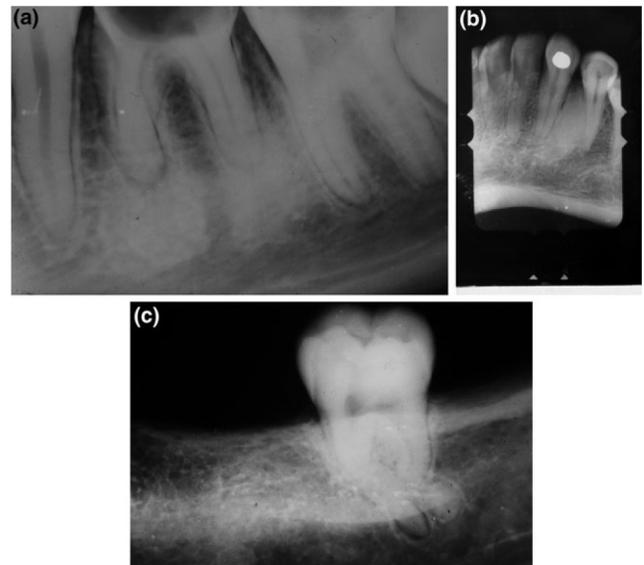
Preoperative radiographs showing potential difficulty in extraction. A, Cemental hyperplasia and condensing osteitis. B, Enostosis. C, Dilacerated roots. (Courtesy of Sambrook PJ, Goss AN: Contemporary exodontia. *Austral Dent J* 63:S11-S18, 2018.)
